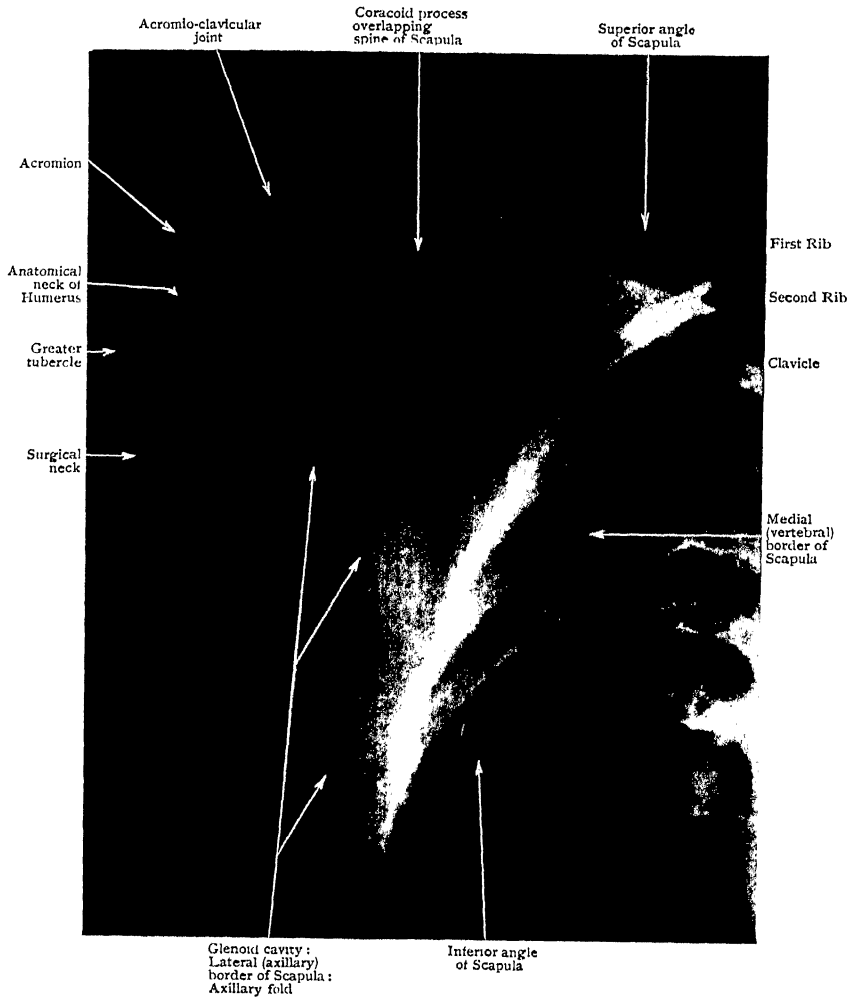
Radiograph of Shoulder Region of man aged 29.
